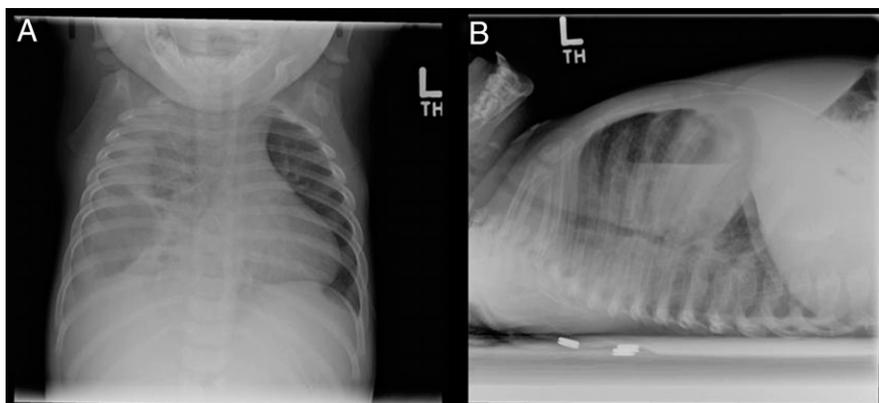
A, The posterior-anterior view of the chest radiograph demonstrating the large right-sided pleural effusion with consolidation in the right lung base. B, The cross-table lateral view of the chest radiograph demonstrating the air-fluid level present in the right lung cavity.
